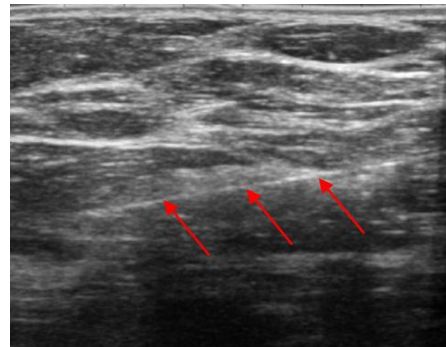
an example of 2D ultrasound image containing a needle (marked by arrows) in the breast tissue.
